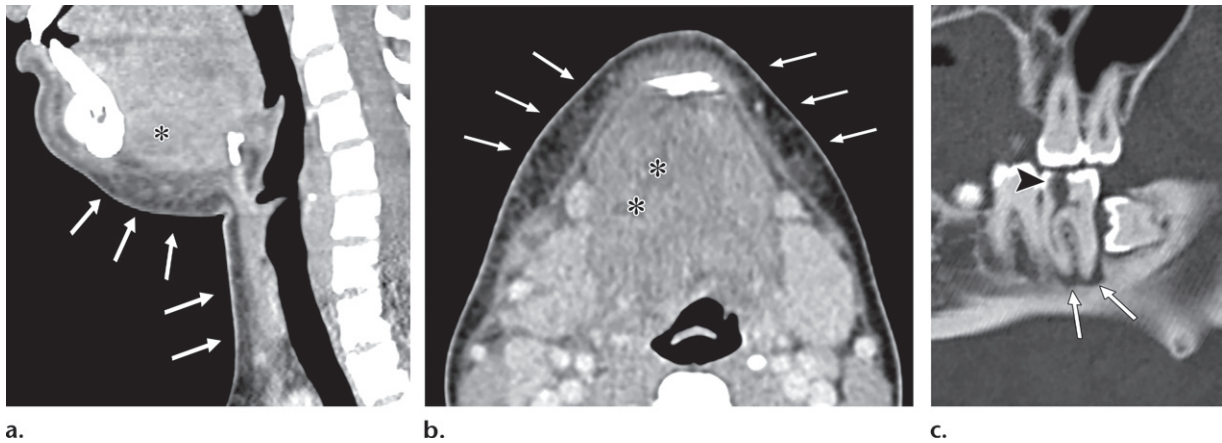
Ludwig cellulitis. (a, b) Sagittal (a) and axial (b) contrast-enhanced CT images (soft-tissue window) reveal a small fluid collection with peripheral enhancement (*), with fat stranding and edema extending bilaterally within the submandibular, sublingual, and submental spaces (arrows). (c) Sagittal CT image (bone window) demonstrates a carious lesion affecting the pulp chamber (arrowhead) of the lower second molar with apical periodontitis (arrows), therefore revealing the cause of the infectious process.
